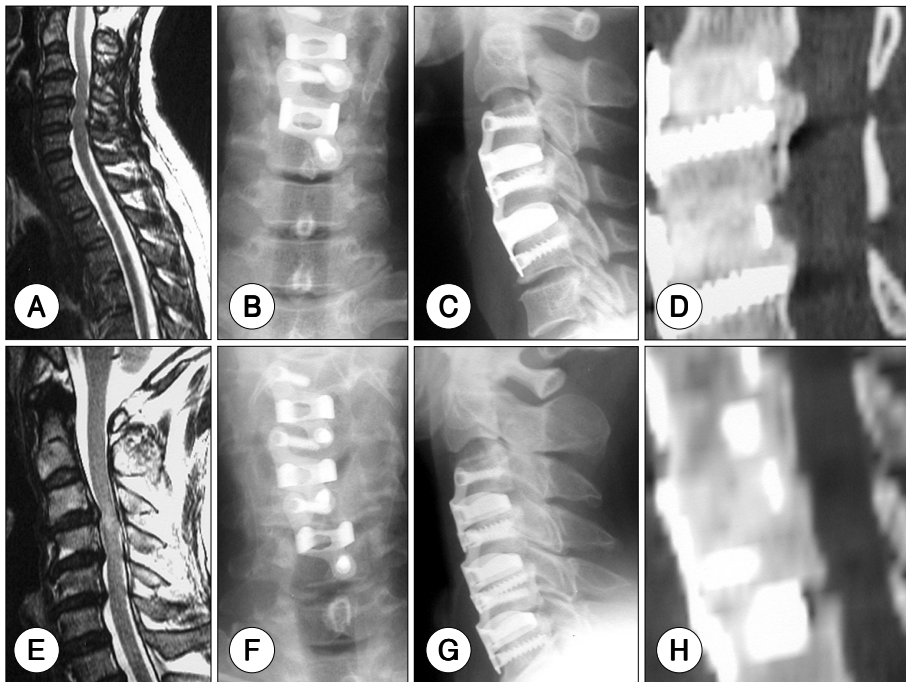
Two levels (A-D) and three levels (E-G) anterior cervical fusion with PCB® instrument. A : Preoperative sagittal T2-weighted magnetic resonance image showing herniated cervical discs with stenosis at C3/4, C4/5 in a 60-year-old woman. B and C : Plain cervical X-rays six-month after operation. D : Computed tomographic scan twelve-month after operation showing complete bony fusion. E : Preoperative sagittal T2-weighted magnetic resonance image showing herniated cervical discs with stenosis at C3/4, C4/5, and C5/6 in a 54-year-old man. F and G : Plain cervical X-rays eight-month after operation. H : In computed tomographic scan twelve-month after operation, solid bone fusion between the endplates is demonstrated.
